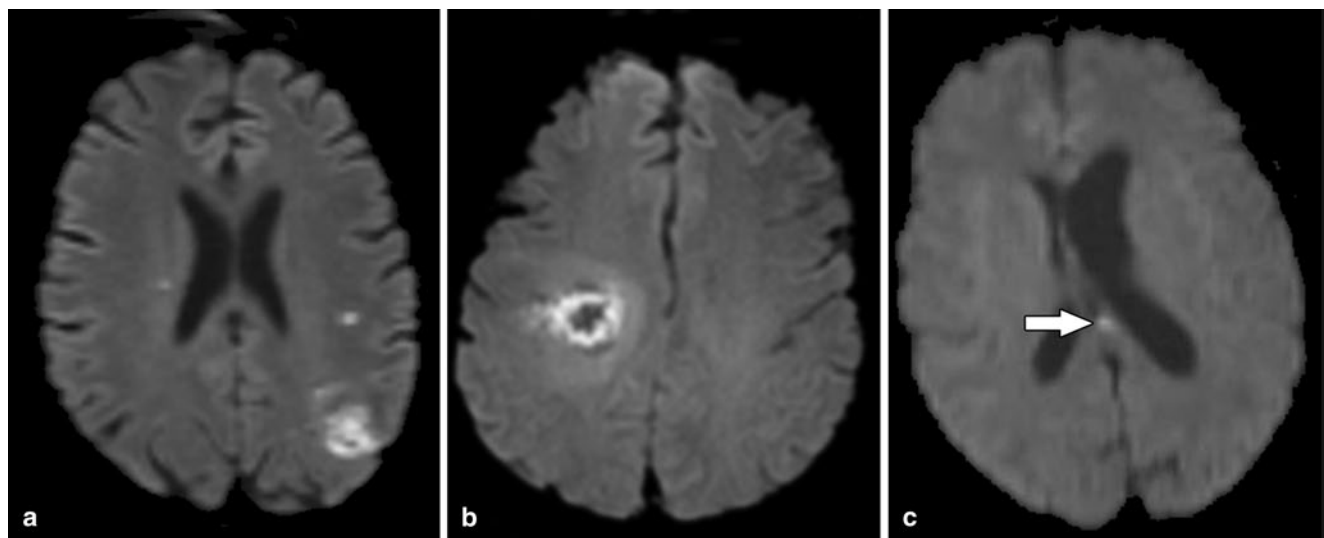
Patterns of reduced diffusion in fungal infection may be heterogeneous, ring-like, or punctate. a Axial DWI sequence shows heterogeneous diffusion restriction in the lesion at the left posterior parietal lobe. The patient was a 37-year-old woman who was intoxicated and fell, with normal head computed tomography (CT) on admission. She was treated with glucocorticoid therapy for acute alcoholic hepatitis and developed mental status changes on hospital day 11. b Axial DWI sequence shows ring-like reduced diffusion in the posterior right frontal lobe. The patient was a 61-year-old man with a history of neck cancer and on dexamethasone for radiation edema who presented
